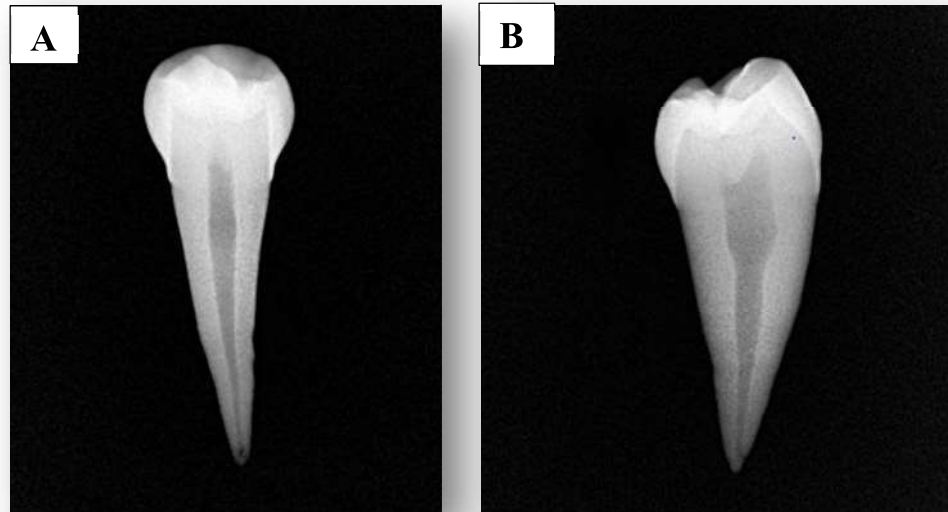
(A) Buccolingual periapical radiograph, (B) Mesiodistal periapical radiograph
